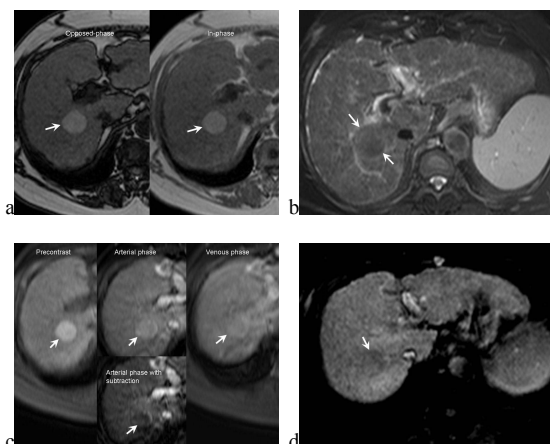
A 57-year-old female with a well-differentiated HCC (arrow) at segment 8 of the liver underwent gadoxetic acid-enhanced MR imaging and liver biopsy. a) The tumor depicted hyperintense on both opposed-phase and in-phase T1-weighted imaging. b) The tumor showed isointense to hypointense on T2-weighted with fat suppression imaging. c) The tumor showed no obvious enhancement on arterial phase and no contrast washout on venous phase of the dynamic 3D-T1-weighted imaging. No obvious arterial enhancement of the tumor in the arterial phase with subtraction imaging is found. d) The HCC showed hypointense on the hepatocyte-phase T1-weighted with fat suppression imaging.
